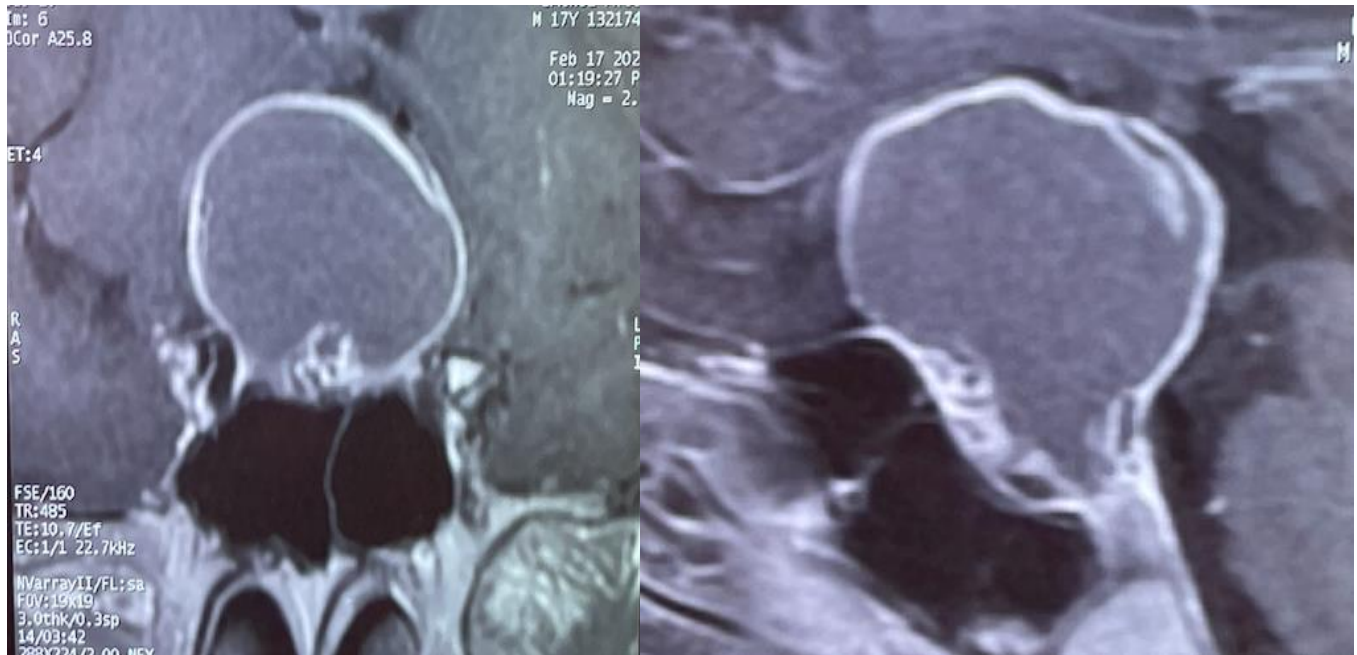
Sagittal and Coronal hypothalamic-pituitary MRI showing a sellar tumor process measuring 34x27x21mm
